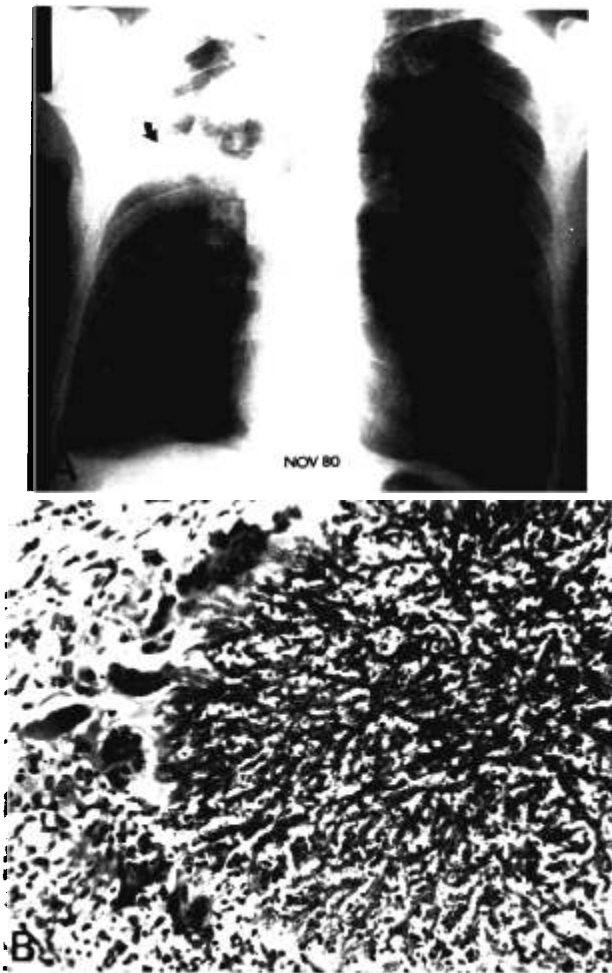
A. PA Chest Roentgenogram (November 1980). A large cavity with an air-fluid level is evident within the right upper lobe. An intracavitary mass compatible with a mycetoma is present (arrow). B. A section of the wall of patient's right upper lobe abscess cavity demonstrating tissue invasion by numerous septate hyphae surrounded by multinucleated giant cells and other inflammatory cells (260 ×).
